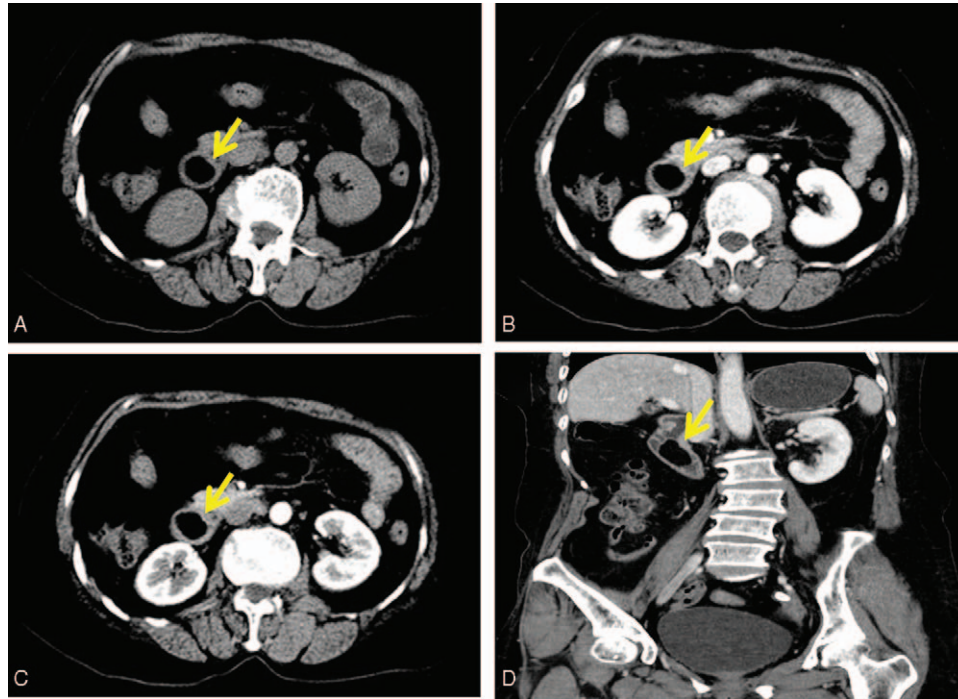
CT findings of duodenal lipoma. A. CT scan shows a circular fat-like density shadow of the descending duodenum (arrow) with a size of about 2.1 cm × 1.7 cm, and a CT value of −102 HU. B (arterial phase)–C (venous phase) enhanced scan arteriovenous phase tumors showed no significant enhancement (arrow). D. The coronal position visually shows a class of round lipid tumors in the descending duodenum (arrow). CT = computed tomography.
